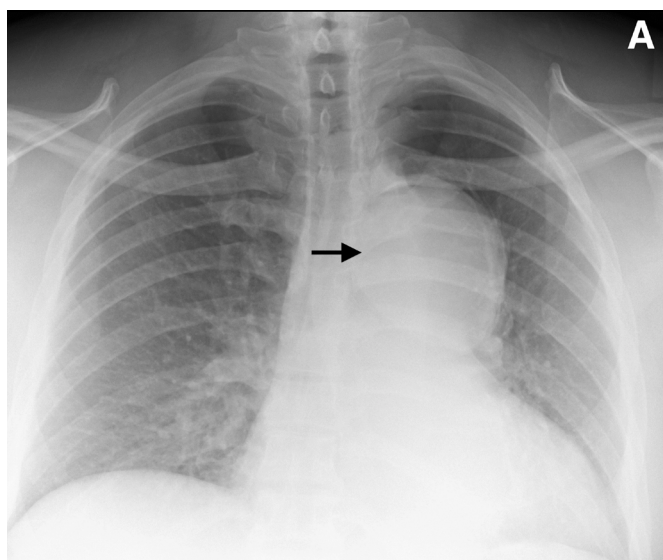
A, Chest radiograph revealing a left mediastinal mass. B, Complex thoracic aortic dissection originating at aortic root. 1) true lumen 2) acute dissection 3) acute dissection 4) chronic dissection
